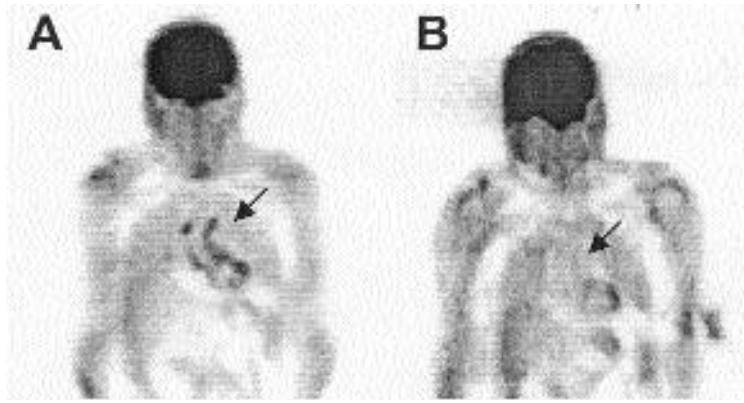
Coronal FDG PET slices (2 cm thickness) through the ascending aorta region of patient 4. (A) Before treatment, avid FDG uptake in the aortic wall (arrow) is shown. (B) During clinically quiescent disease (after 22 weeks of prednisolone, starting with 60 mg once daily, and at that moment 20 mg once daily) nearly all uptake has disappeared. Background uptake is present in the myocardium.
